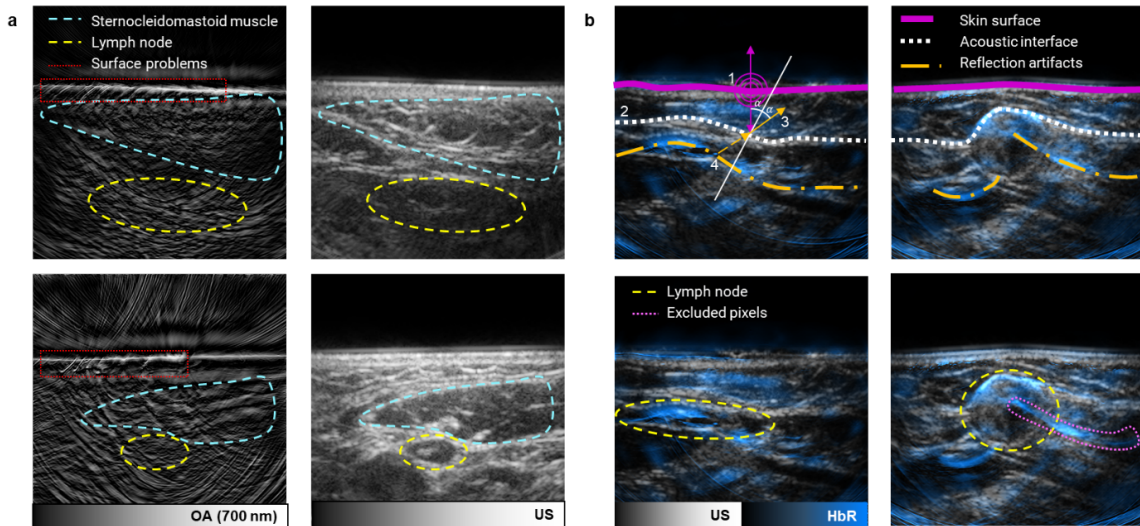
Image quality issues and reflection artifacts. a, Two examples of surface contact issues (red dotted line) and occlusion of the lymph nodes (yellow dashed line) by the sternocleidomastoid muscle (aqua dashed line). Both problems contribute to bad image quality and too weak signal in the lymph node region, as seen in the left optoacoustic images ($\lambda=700$ nm). Ultrasound images are shown on the right. b, Two examples of the reflection artifacts and a scheme of the physical mechanism behind the phenomenon. An acoustic pressure pulse is emitted from an optical absorber in all directions (1). Part of the wave travels directly to the detectors, but part propagates into the tissue. Acoustic interfaces inside the tissue (2) act as reflectors. The wave gets reflected from the interface and travels outwards to the transducers (3). The reconstruction algorithm is oblivious to the reflections affecting the incoming waves and assumes the signal came along a straight line from an absorber at a distance given by the travel time and the speed of sound (4). A reflection artifact is thus observed behind the reflecting interface at a distance proportional to the distance between the interface and the true pressure wave origin. The most observed reflection is of the skin where the light fluence is highest, and thus, the optoacoustic signal is strongest. The skin reflection mainly affects the images of deoxyhemoglobin. This happens because the main absorber in the skin is melanin, whose absorption spectrum coincides with deoxyhemoglobin in the MSOT wavelength range. Abbreviations: LN+, malignant lymph node; LN-, benign lymph node. Figure reproduced from *Vonk, Kukačka et al. "Multispectral optoacoustic tomography for in vivo detection of lymph node metastases in oral cancer patients using an EGFR-targeted contrast agent and intrinsic tissue contrast: A proof-of-concept study." Photoacoustics 26 (2022): 100362.*
